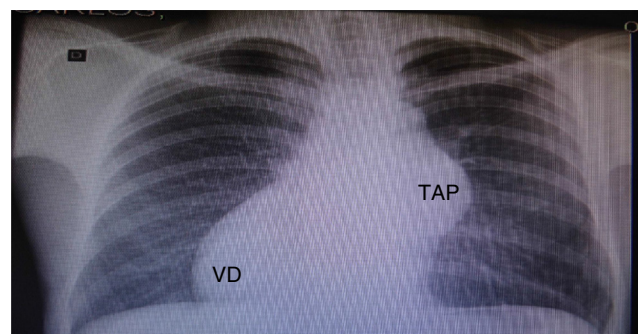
Chest X-ray: TAP aneurysm, increased VD, and deviation of the cardiac area to the right. TAP, pulmonary artery trunk; VD, right ventricle.
